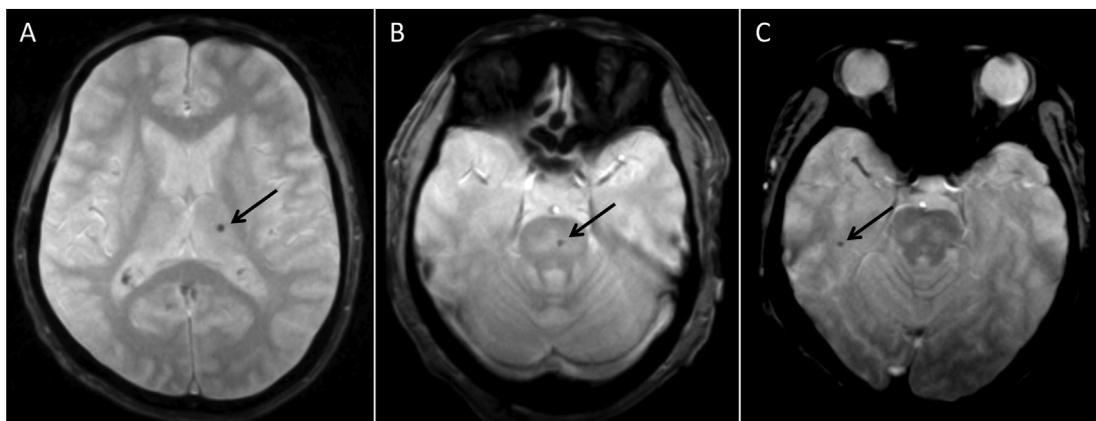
Representative images of CMBs on gradient echo T2*-weighted MRI. CMBs are seen in the thalamus (A), the pons (B) and the temporal lobe (C).
